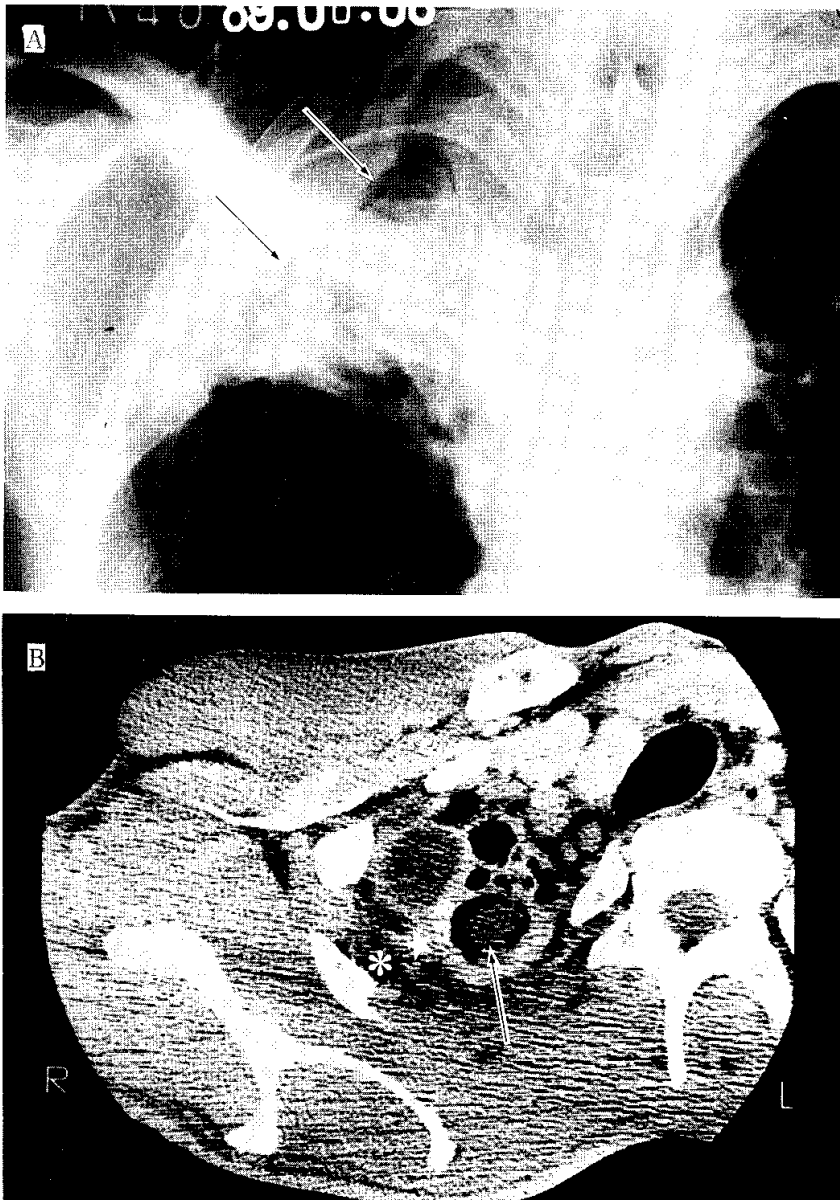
Images of a 53-year-old woman with a thick apical opacity (apical cap) with an intracavitary aspergilloma. A. Chest radiograph shows a homogeneous 2-cm thick apical opacity that is demarcated by an air meniscus (arrows) marginating the upper aspect of the intracavitary mycetoma. B. High-resolution CT at the level of the black line in (A). The homogeneous opacity seen laterally on the chest radiograph at the black line consists of extrapleural fat laterally (asterisk) and thickened pleura and atelectatic lung medially (star). Note the air-containing intracavitary fungus ball (arrow) and ectatic bronchi medially. (Im J-G, Webb WR, Han MC, Park JH. Apical opacity associated with pulmonary tuberculosis: high-resolution CT findings. *Radiology* 1991;178:727-731. Reprinted with permission.)
